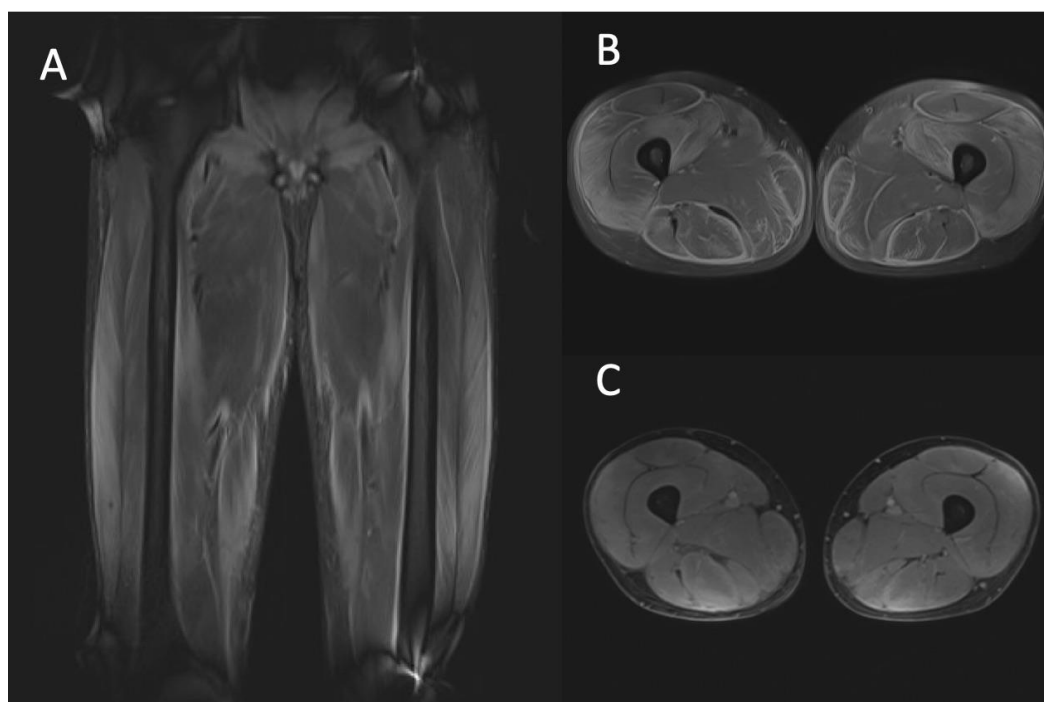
MRI of thighs in our patient and demonstrating diffuse hyperintensities among muscles of both thighs in coronal FAT-SAT T2 sequence (A), and axial section FAT-SAT T2 (B) with enhancement that predominate posteriorly on post contrast FAT-SAT T1 (C)
